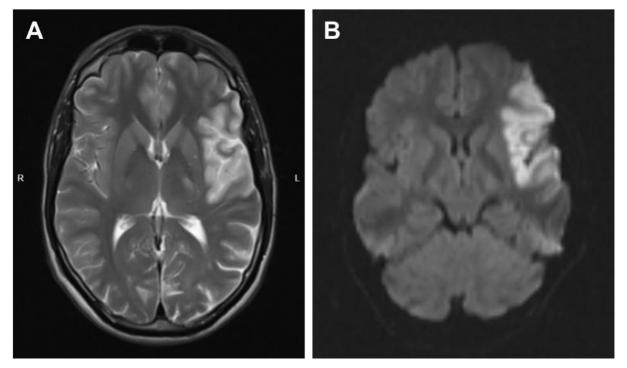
(A) MRI brain, T2 weighted and (B) DWI sequence showed an acute left MCA infarct.
